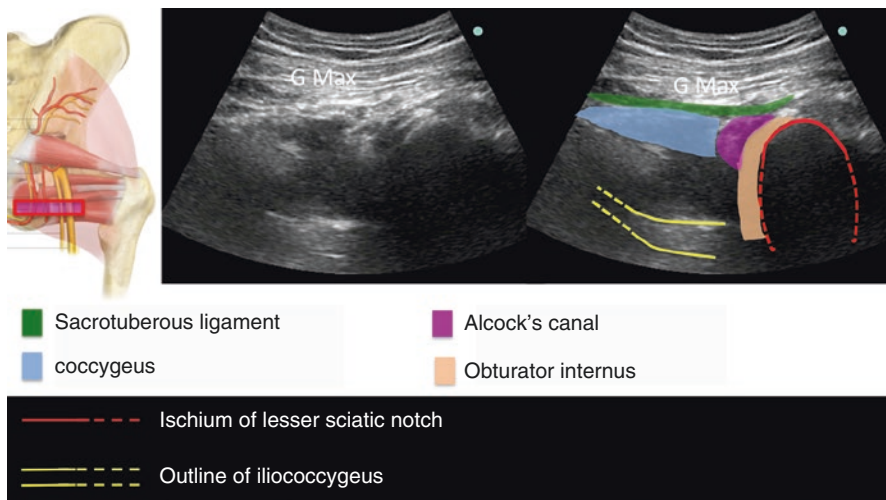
Figure showing the ultrasound probe and the corresponding sonography. (Reprinted with permission from Philip Peng Educational Series)
